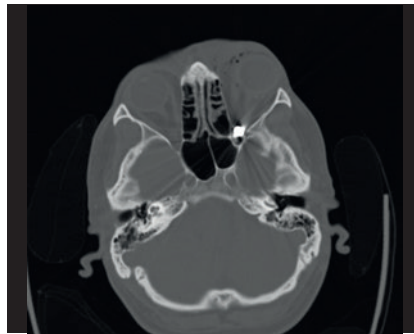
Computed tomography scans of the head showing the presence of a foreign body with metal effect in the right posterior orbital fossa.
